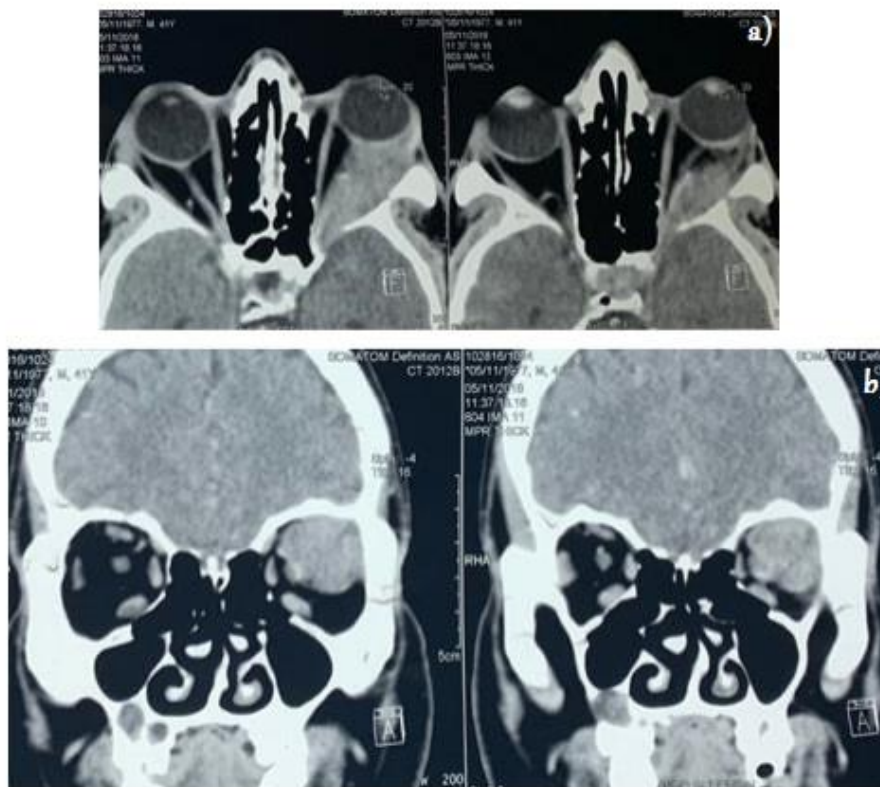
(a) Axial (b) Coronal of CT orbital scan of a left intraorbital process.
